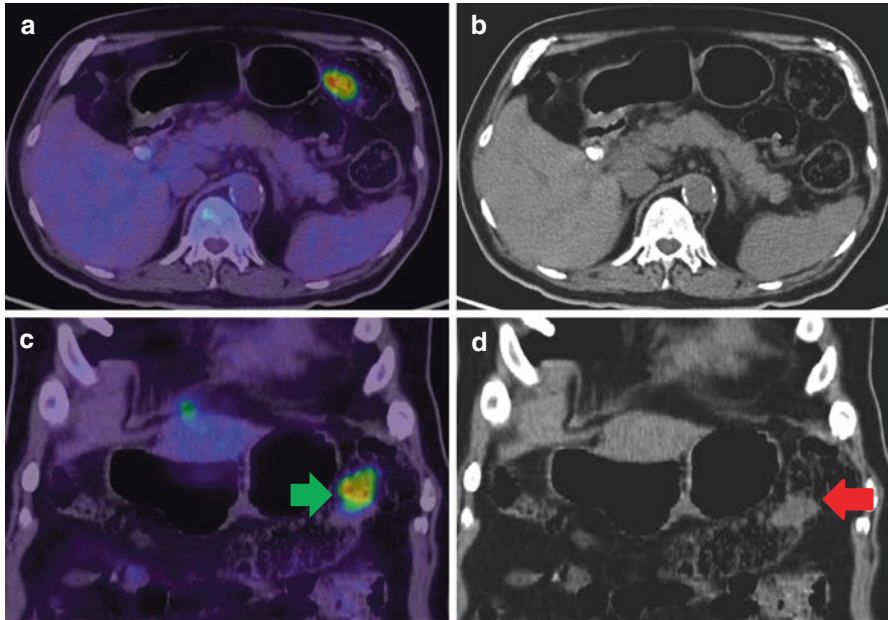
Misregistration due to bowel movement. Intensely FDG concentration in the left third of the transverse colon (a) with no corresponding lesion seen in CT (b). Careful review of coronal images (c - coronal fused PET/CT and d - coronal CT images) reveals the misregistration (green arrow—FDG uptake and red arrow, lesion in CT)
